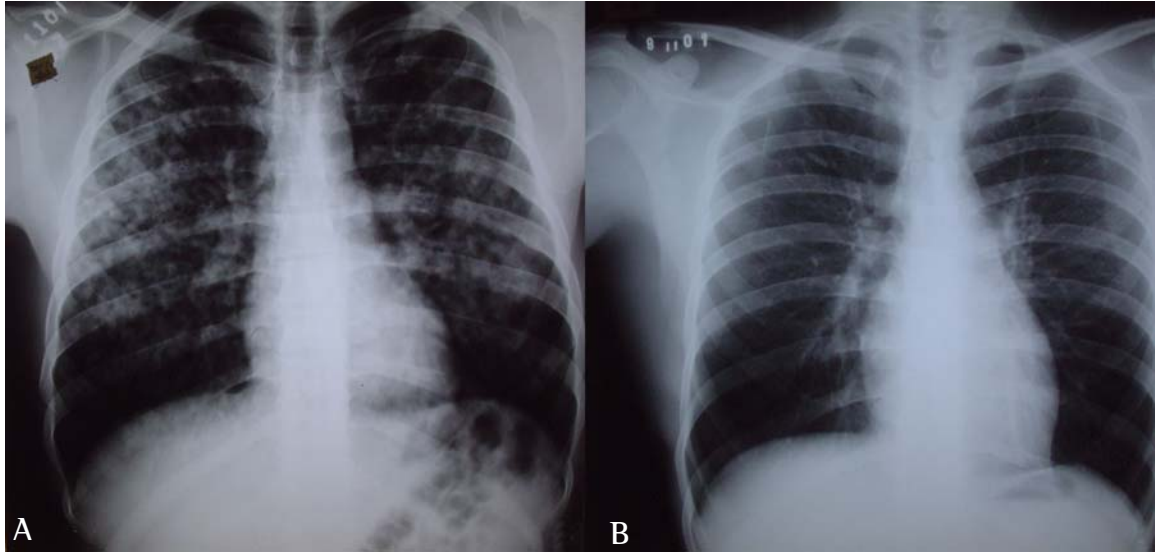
A) Anteroposterior chest X-ray: interstitial-alveolar infiltrate, bilateral, predominantly in the middle lobes. B) Anteroposterior chest X-ray, seven days after exposure: normal result.
